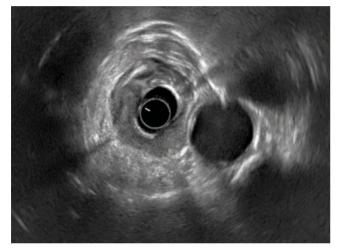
Endoscopic ultrasound image demonstrating a T3 oesophageal cancer posteriorly.
